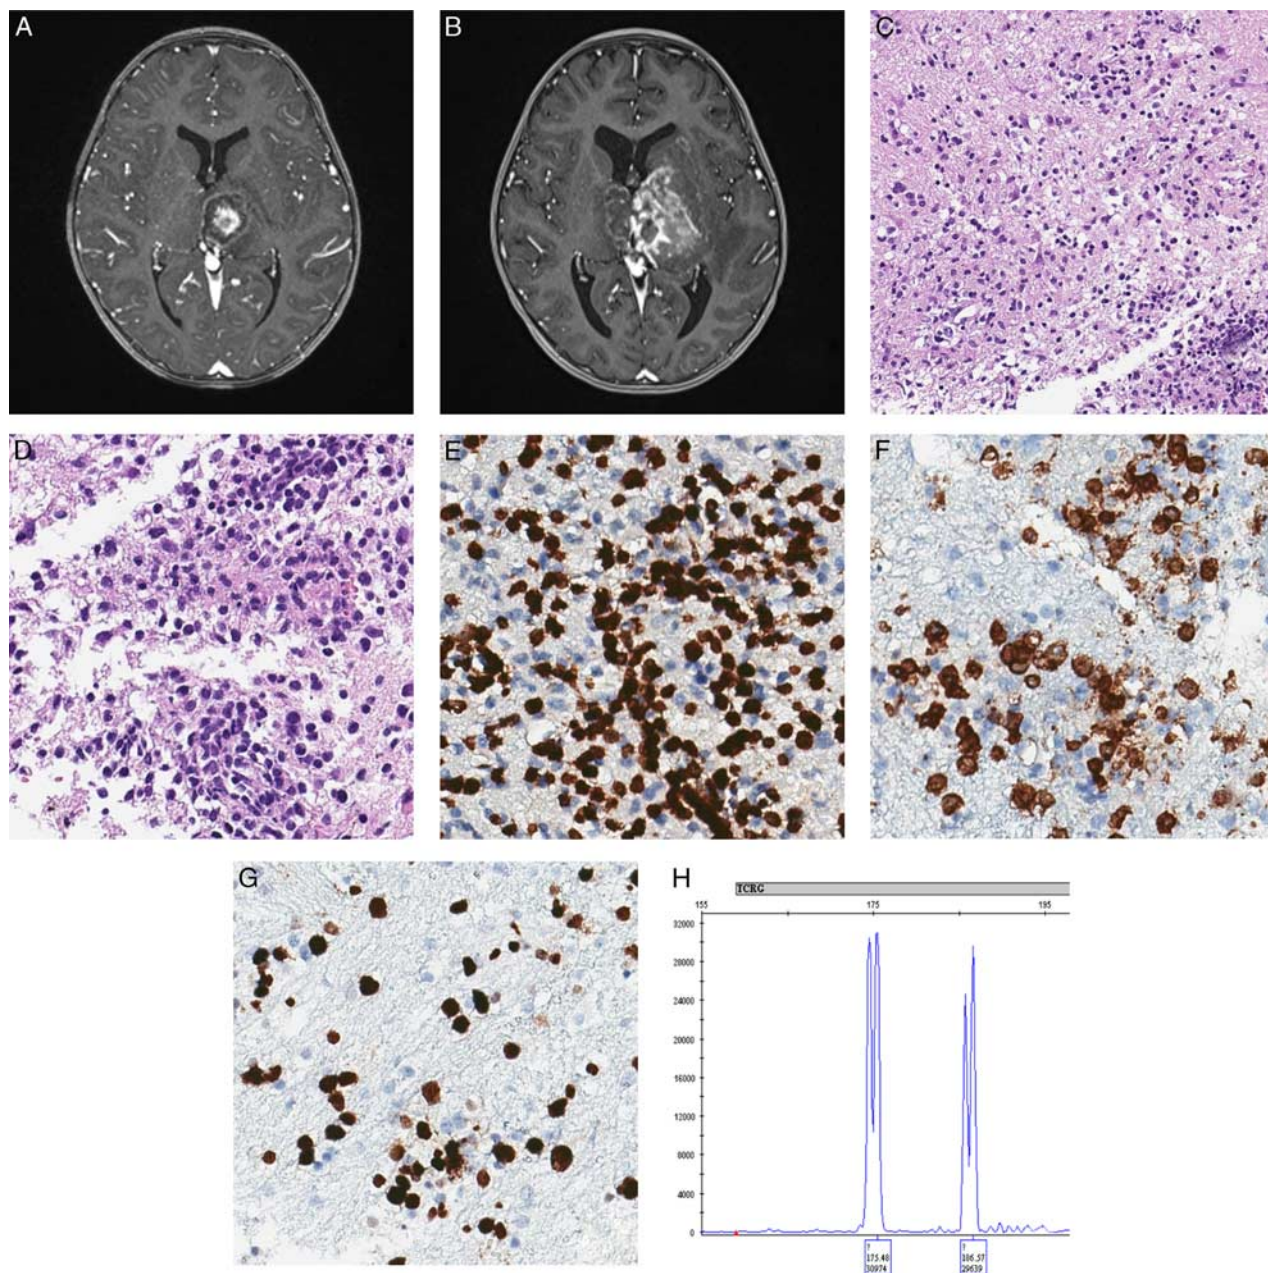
Representative images of case 10 (pediatric peripheral T-cell lymphoma, not otherwise specified). A, Initial brain magnetic resonance imaging revealed a 2-cm T2 high SI lesion in the left thalamus. B, One month later, the left thalamic lesion extended into the right thalamus, left basal ganglia, and bilateral brain stem. In biopsy taken after steroid treatment, brain parenchyma was infiltrated by small lymphoid cells (C, D), expressing CD3 (E) and CD8 (F) with Ki-67 (+) proliferative activity (G). H, T-cell monoclonality was observed in a *TCRG* gene rearrangement study.
